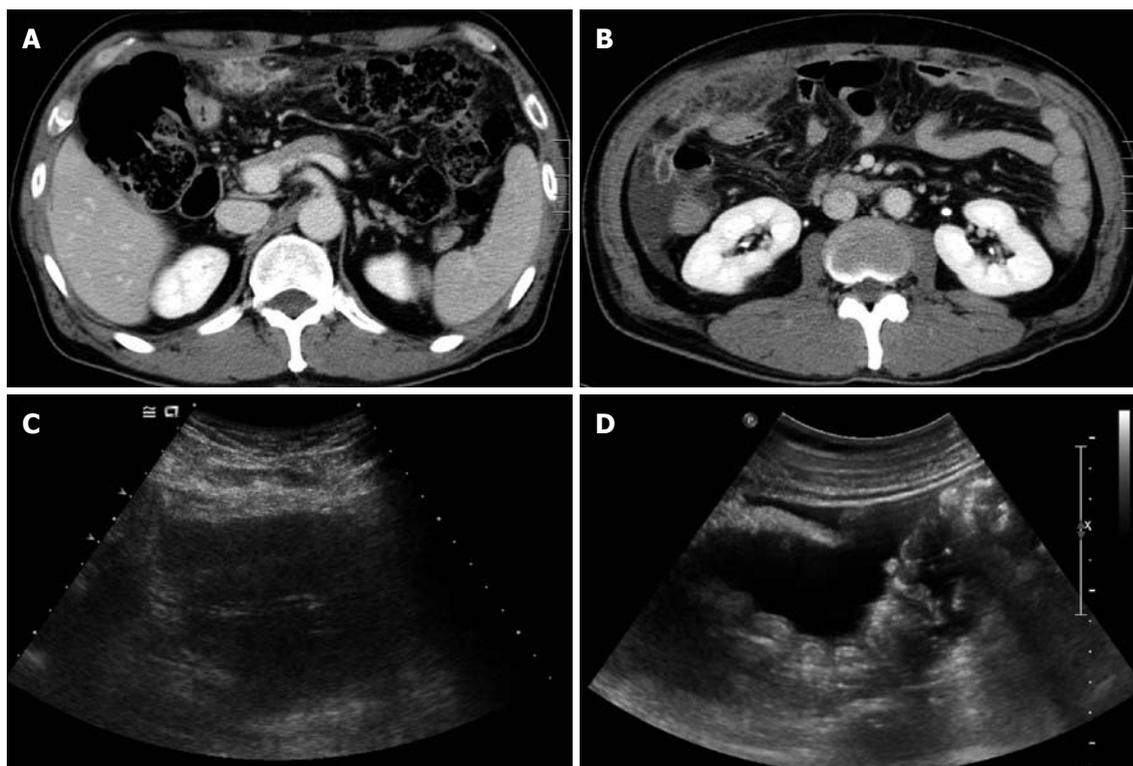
Abdominal computed tomography (CT) and ultrasonography (US). A: Initial abdominal CT revealed a mass-like lesion of about 7 cm × 3 cm at the greater omentum; B: Abdominal CT follow-up after 1 wk antibiotic therapy showed an increased omental mass lesion, with a shift to the right lower abdomen, and ascites; C: Abdominal US showed a heterogeneous echoic mass at the greater omentum, and ascites; D: Multiple round nodules at the peritoneum and ascites.
